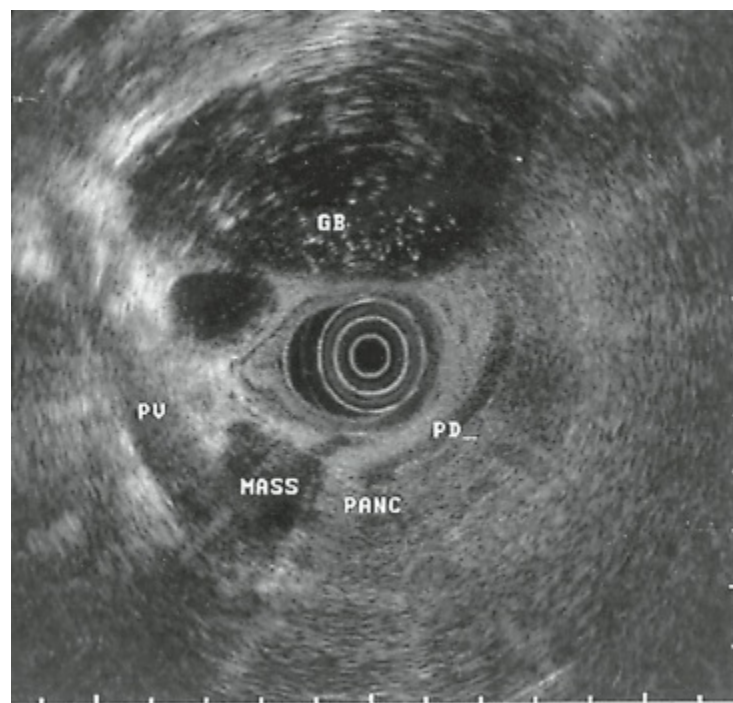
Endoscopic ultrasonogram of a 2.2-cm mass in the head of the pancreas. The transducer tip is located in the duodenum. The dilated common bile duct and gallbladder (GB) can be seen at the top of the image. The pancreatic duct (PD) is also dilated. The mass involves the portal vein (PV).
